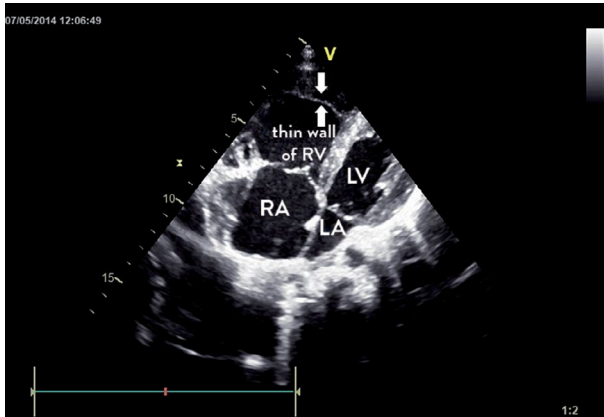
Echocardiography of Uhl's anomaly at admission; RA = right atrium; RV = right ventricle; LA = left atrium; LV = left ventricle.
